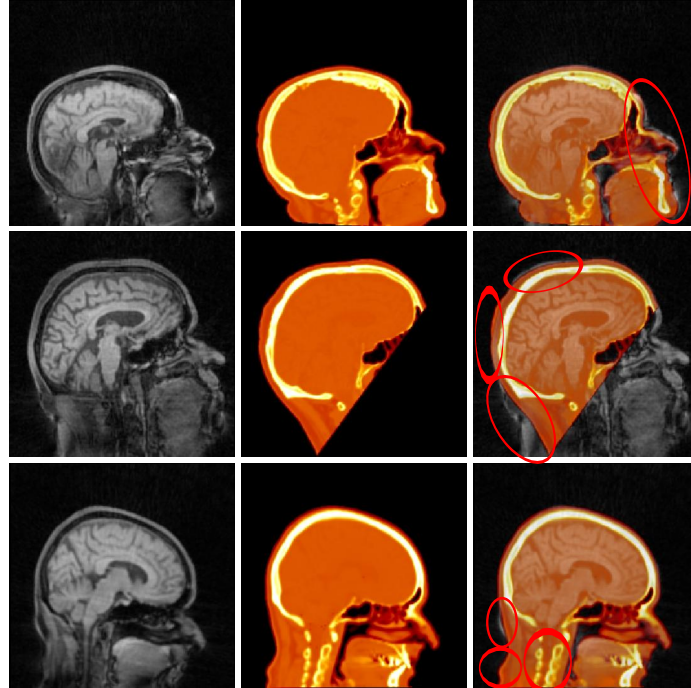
Coregistration problems for 3 different subjects. At left: MR images; at the center: CT images; and at right: fusion of CT and MR images. Ellipsoids point out mismatches between the CT and MR images.
